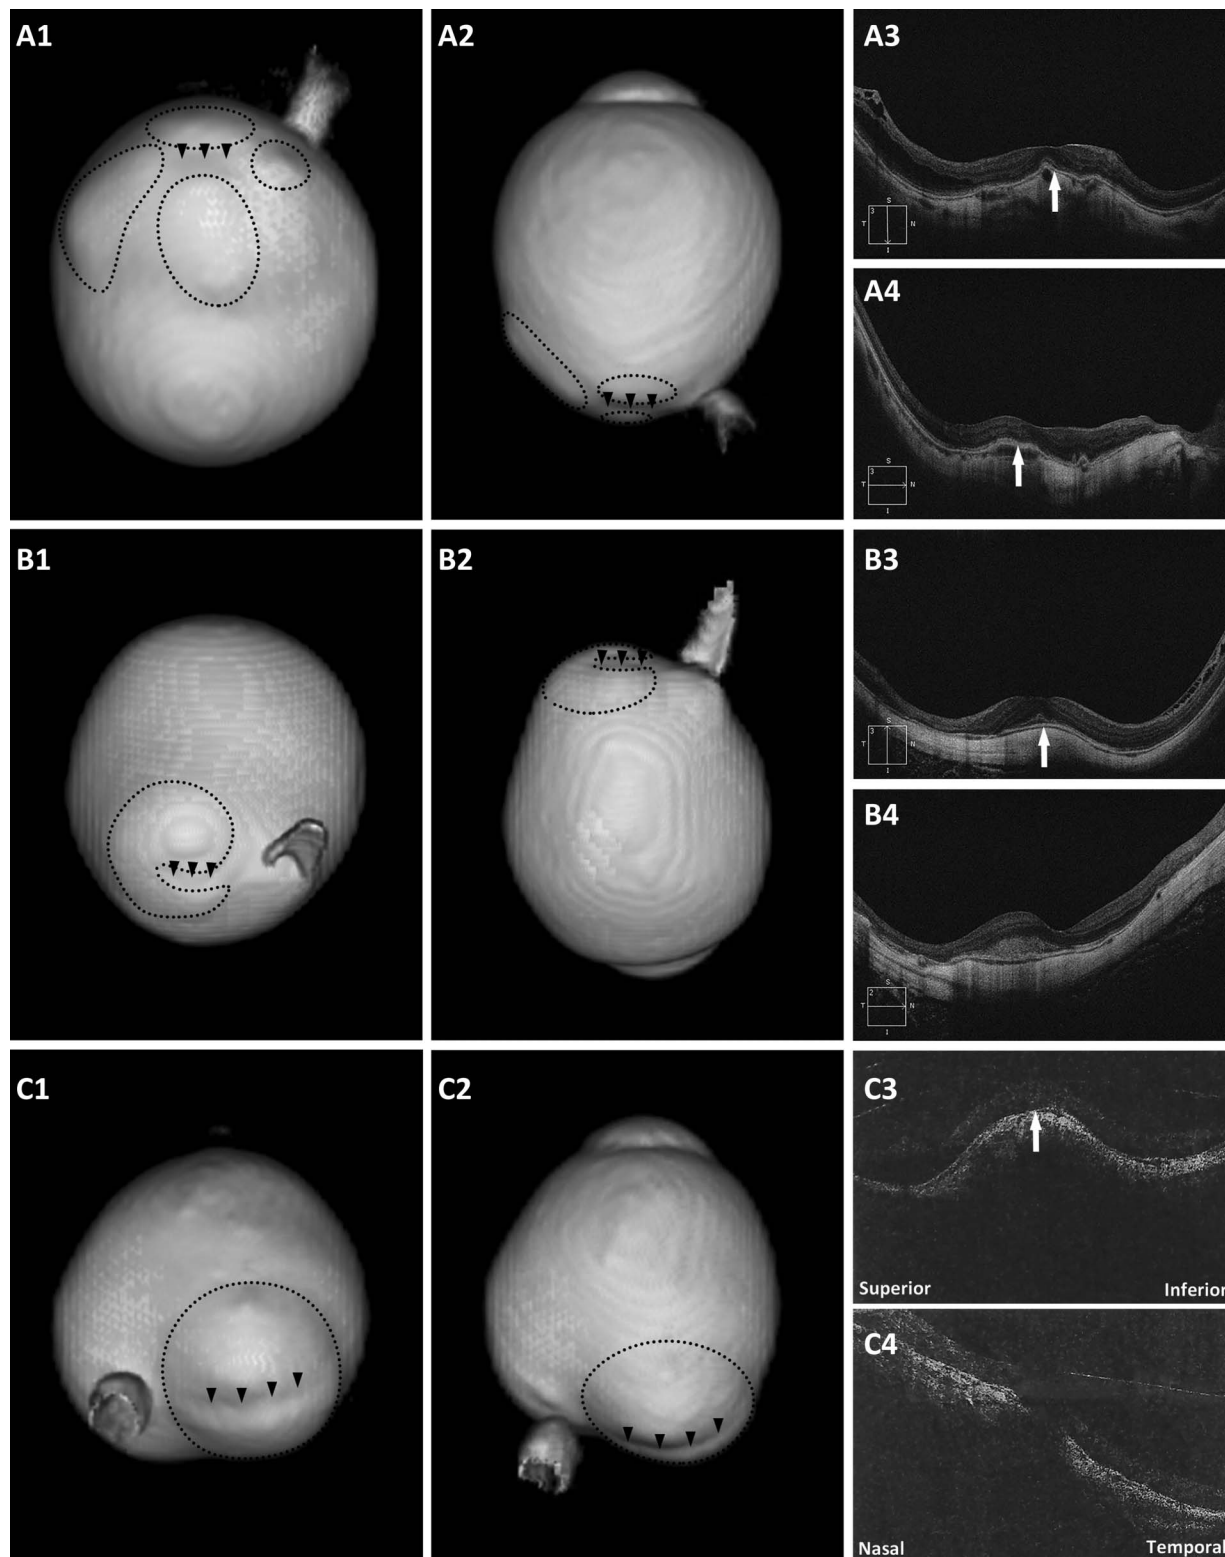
Eyes with a DSM on OCT and a macular inward convexity on 3D MRI. A1 and A2. Posterior view and side view of 3D MRI of the eye. One macular inward convexity (arrowheads) and four distinct staphylomas (circles) around are observed; (A3 and A4) both vertical and horizontal scans show a convex macula (arrows). B1 and B2. Posterior view and side view of 3D MRI of the eye. A band-shaped inward convexity (arrowheads) and a kidney-shaped staphyloma (circle) nearby are observed; (B3) vertical scan shows a clearly convex macula (arrow); (B4) horizontal scan shows a flat macula. C1 and C2. Posterior view and side view of 3D MRI of the eye. The staphyloma (circle) was horizontally split into two parts by the band-shaped inward convexity (arrowheads); (C3) vertical scan shows a clearly convex macula (arrow); (C4) horizontal scan shows a slightly convex macula.
